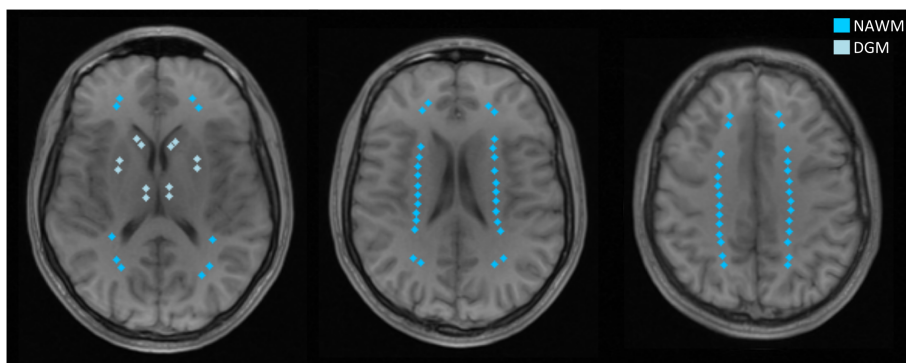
Example of ROI placement in the healthy volunteer MRI data. Shown are three different slices of the first 12° 3D T1W spoiled GRE image. Several small rectangular ROIs were placed in DGM and NAWM.
